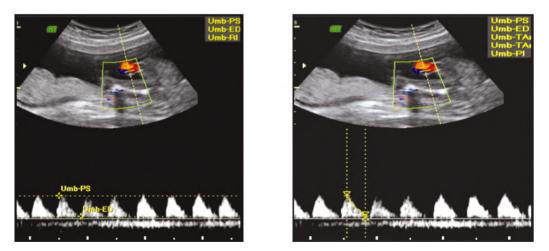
Doppler of the Umbilical artery with RI 0.91.
